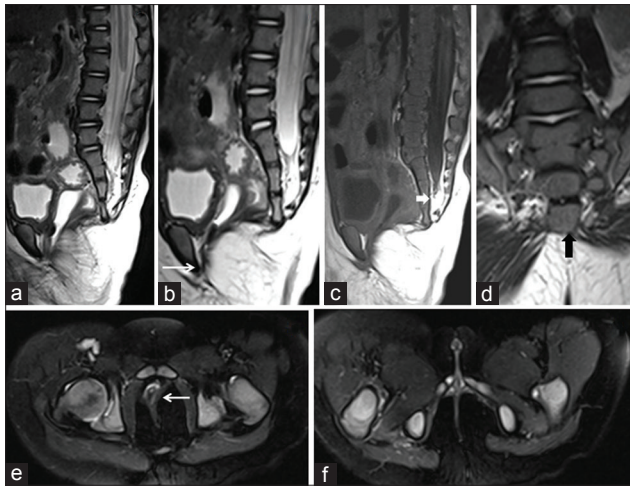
A 7-month-old female infant with fecaluria, (a and b) sagittal T2-weighted image, (c) T1-weighted images show common opening of urethral, vaginal, and atretic anus representing a local anomaly (→ arrow) with intradural lipoma (→ block arrow) in sacral canal causing low-lying tethered cord, where conus ended at L2 vertebral level. (d) Coronal T2-weighted images show complete S5 and coccygeal agenesis with truncation of the thecal sac at S1 vertebral level representing Type III caudal regression syndrome. (e and f) Axial fat-suppressed T2-weighted images show thinned out bilateral perineal muscles with the atrophied perineal body (← arrow).
